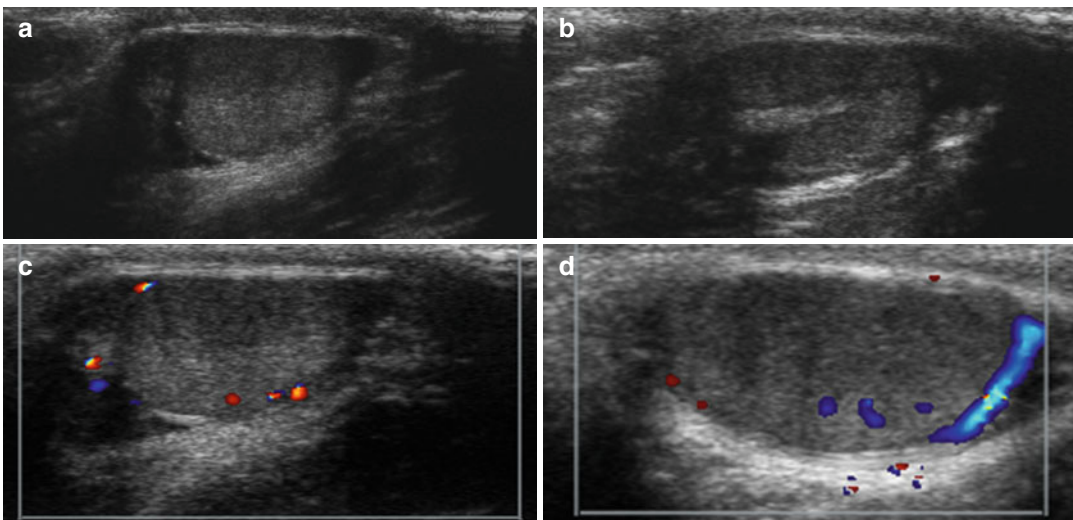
Ultrasound longitudinal scans show the normal anatomy of a 9-year-old child. Note the normal echogenicity of the testis with its Doppler signal (a, c, d), the slight hyperechogenicity of the mediastinum testis (b)
